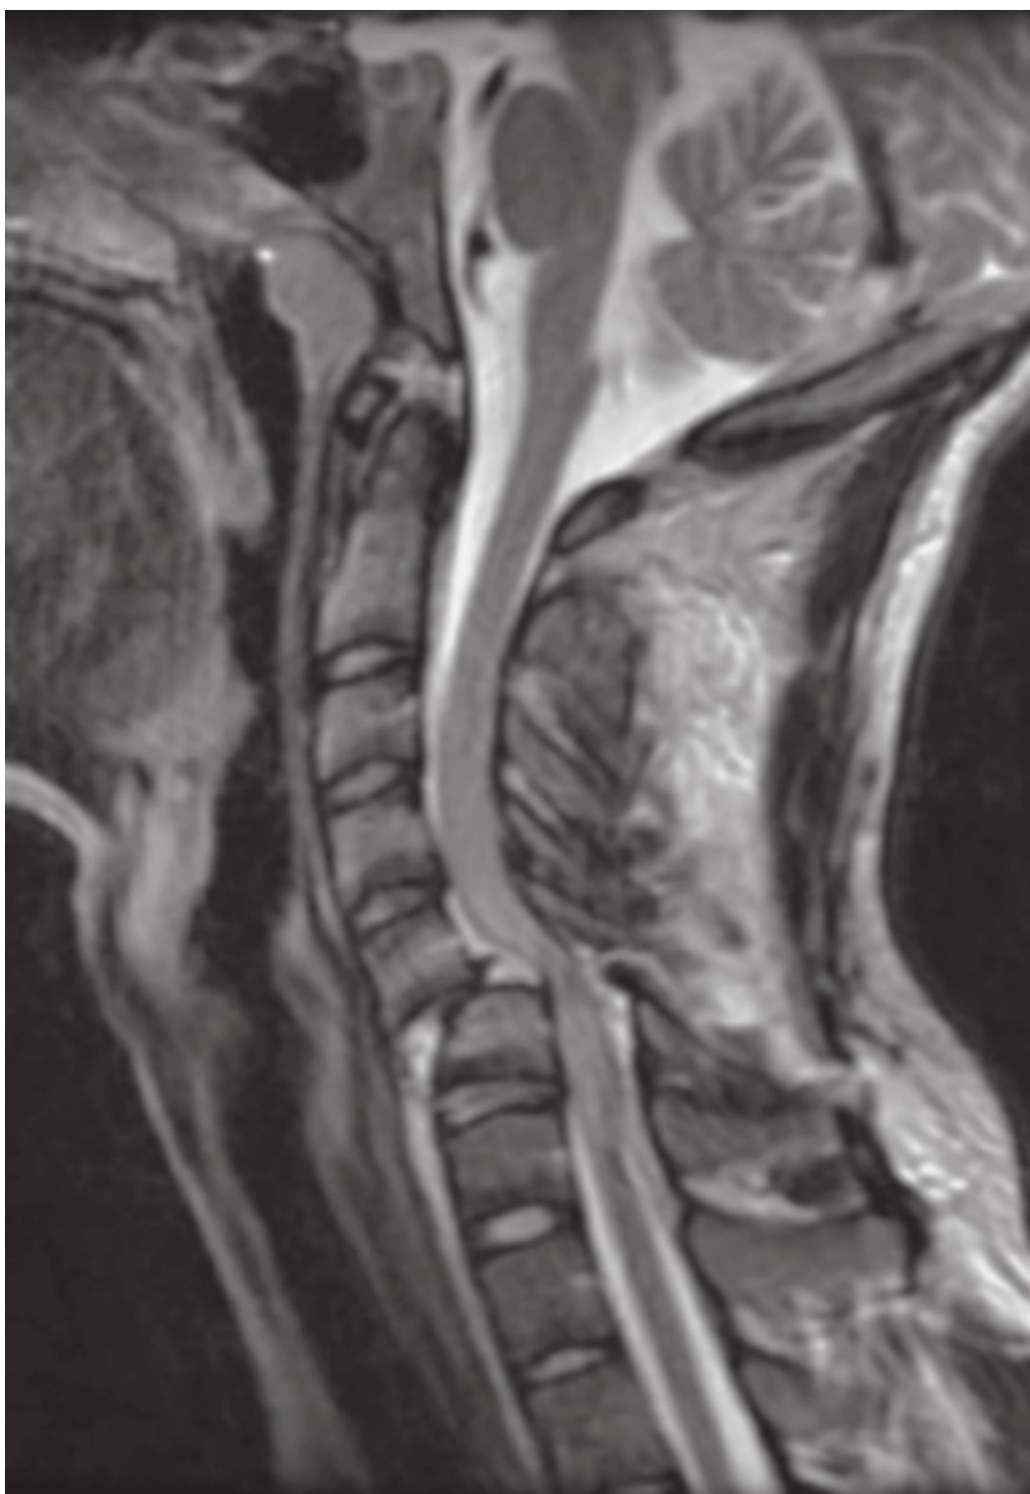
Magnetic resonance imaging of a 32-year-old man who sustained a bilateral C5–C6 facet dislocation with significant cord compromise.
